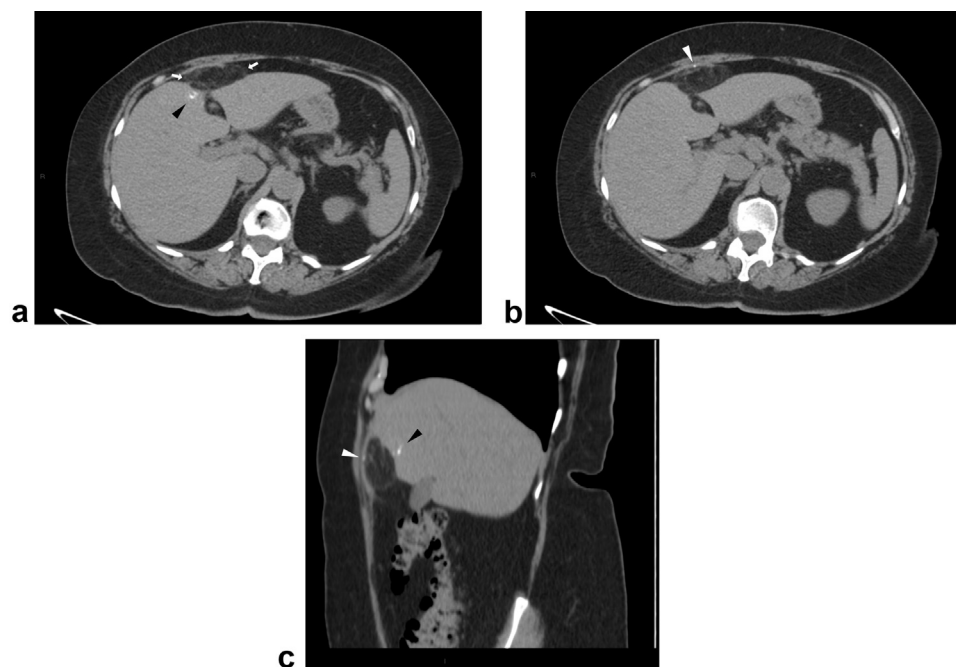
Nonenhanced axial (a, b) CT images with sagittal reconstruction (c) show an oval heterogeneous fat-containing lesion in the greater omental fat (arrows, a) and distribution of iodized oil in the periphery of the liver (black arrowhead in a and c) and in the suspected anomalous branch responsible for the omental infarct (white arrowhead in b and c).
